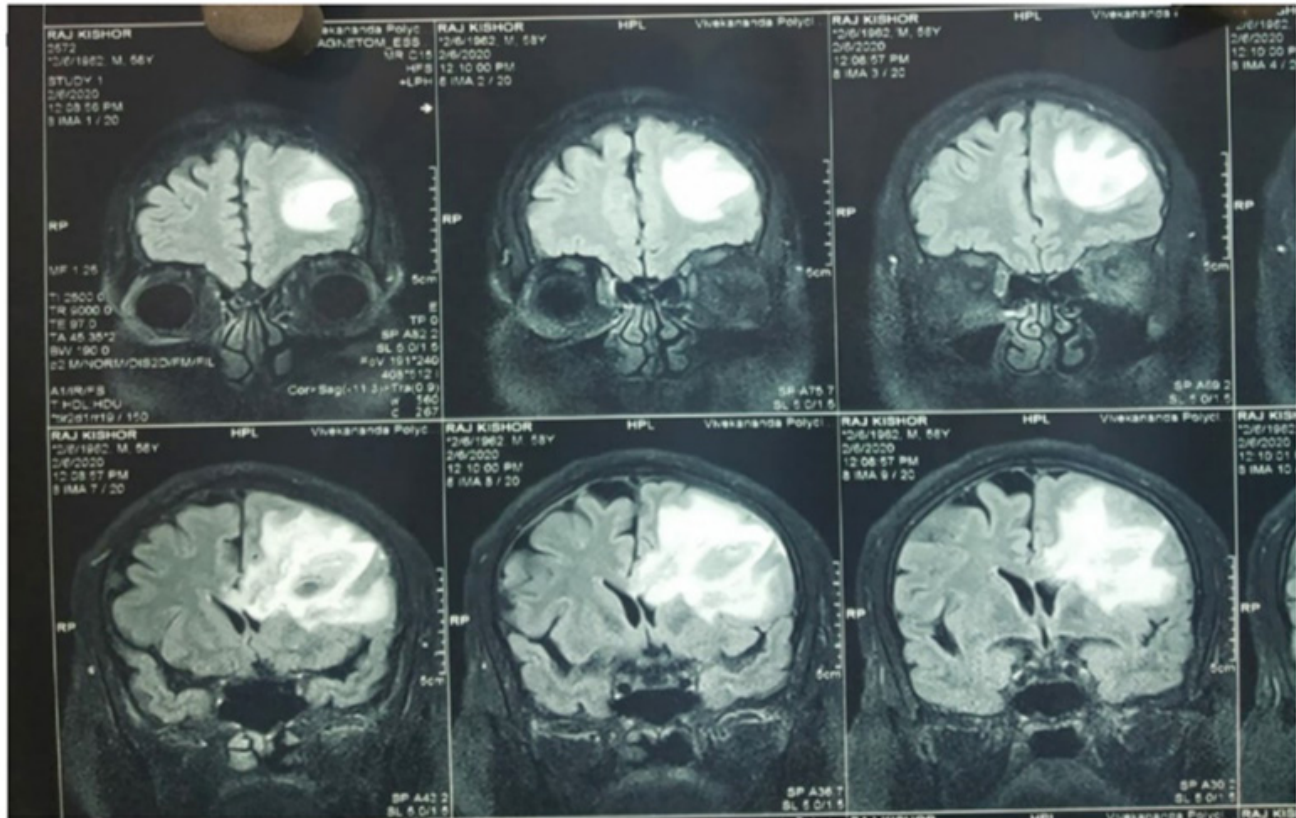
MRI of the brain showing acute hematoma in the left frontal lobe extending medially up to the left lateral ventricle leading to moderate surrounding edema and midline shift to the right side.
